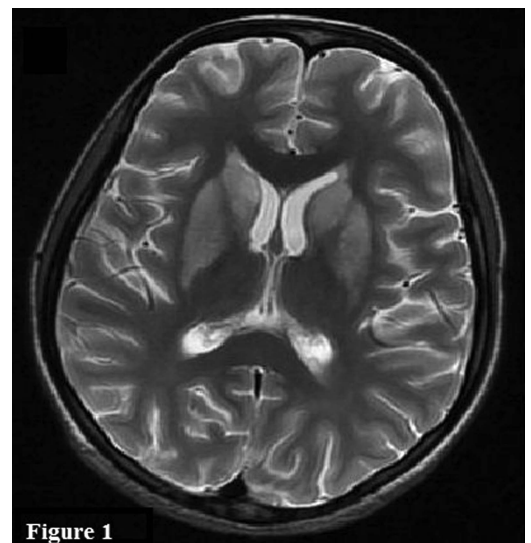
T2-weighted sequence of MRI of the brain showing symmetrical hyperintensity in bilateral basal ganglia.
